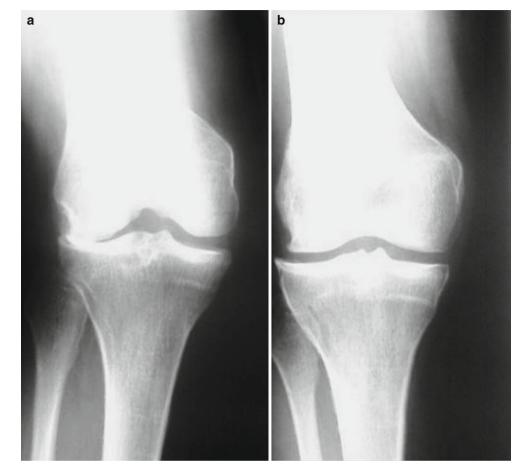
Schuss X-rays PA flexed knee views) (a) have better sensitivity for osteoarthritis diagnosis than full extension X-rays (b), particularly for lateral femorotibial OA
